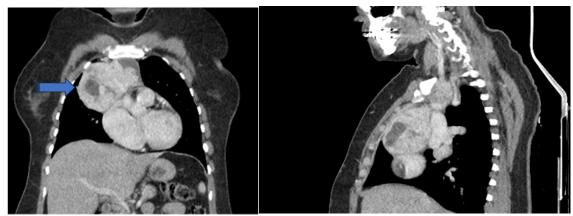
CT image of mediastinal ectopic thyroid tissue not associated with thyroid tissue.
